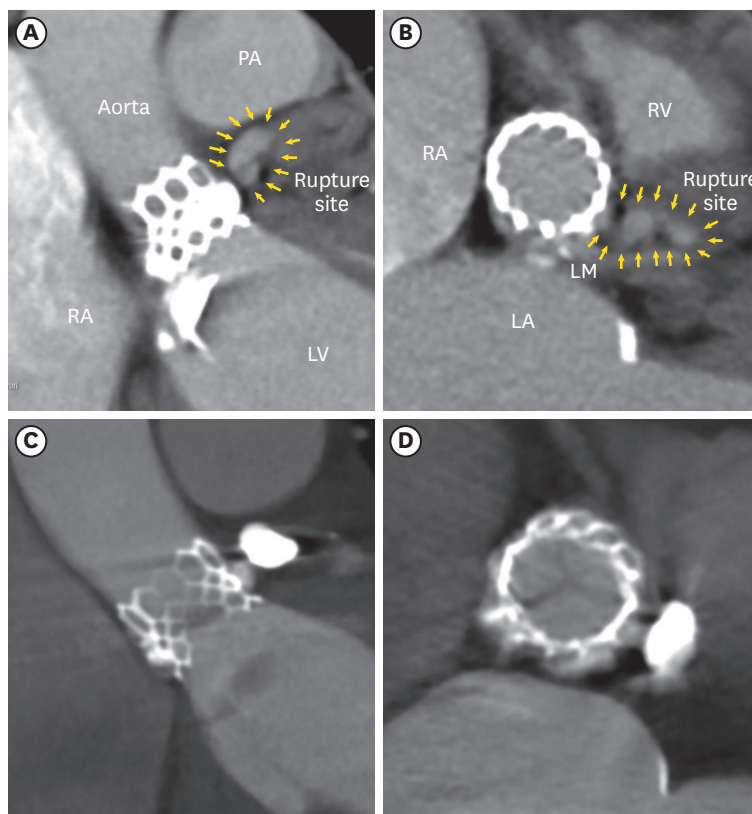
Computed tomography showing the annular rupture on transcatheter aortic valve replacement. Dye leakage is observed in the rupture site on the left coronary cusp side connected to the pericardial space in the perpendicular valve view (A) and en-face valve view (B) (yellow arrows). After coil embolization, no leakage was observed in the perpendicular valve view (C) and in the en-face valve view (D).
